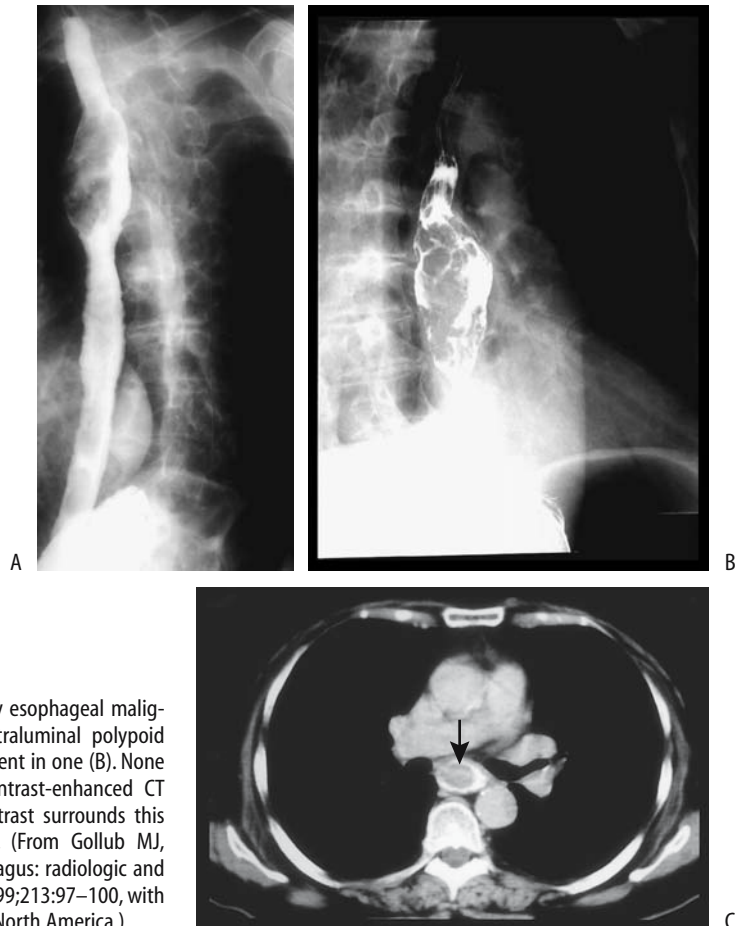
A,B: Two patients with primary esophageal malignant melanoma. Both tumors have an intraluminal polypoid appearance. Linear ulcers or fissures are evident in one (B). None resulted in lumen obstruction. C: Oral contrast-enhanced CT reveals an intraluminal tumor (arrow). Contrast surrounds this primary esophageal malignant melanoma. (From Gollub MJ, Prowda JC. Primary melanoma of the esophagus: radiologic and clinical findings in six patients. *Radiology* 1999;213:97–100, with permission from the Radiological Society of North America.)
